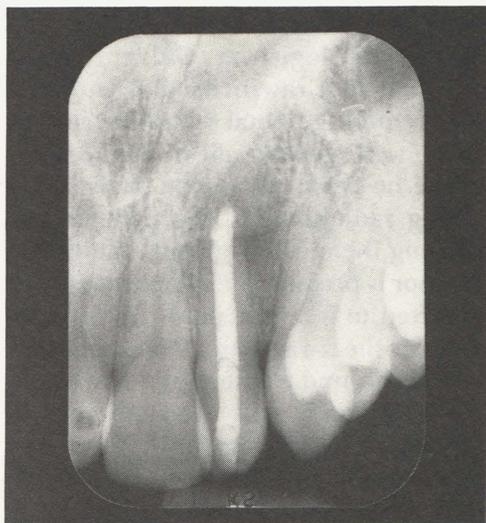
Posttreatment radiograph showing canal obturation with gutta percha and sealer.
